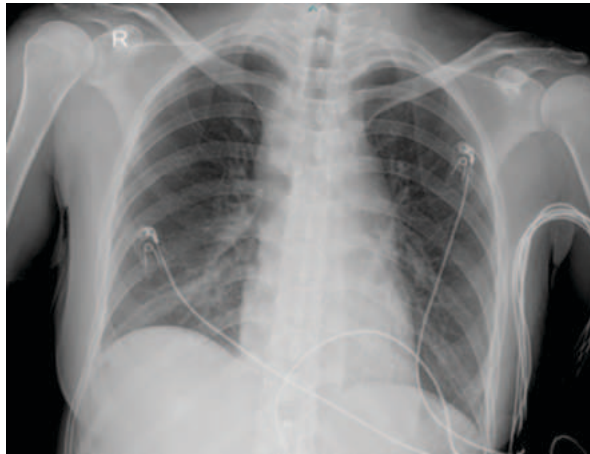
Chest XRay Suggestive of Faint Right Paracardiac Shadow
